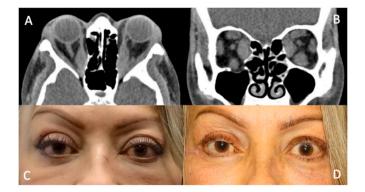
A & B. Computed tomography of the orbits 42 weeks after completion of teprotumumab demonstrating recurrence of extraocular muscle enlargement and proptosis. C. External photograph taken at 33 weeks after completion of teprotumumab, when the patient presented with disease recurrence. D. External photograph taken 1 week after bilateral medial and lateral wall decompression surgeries.
